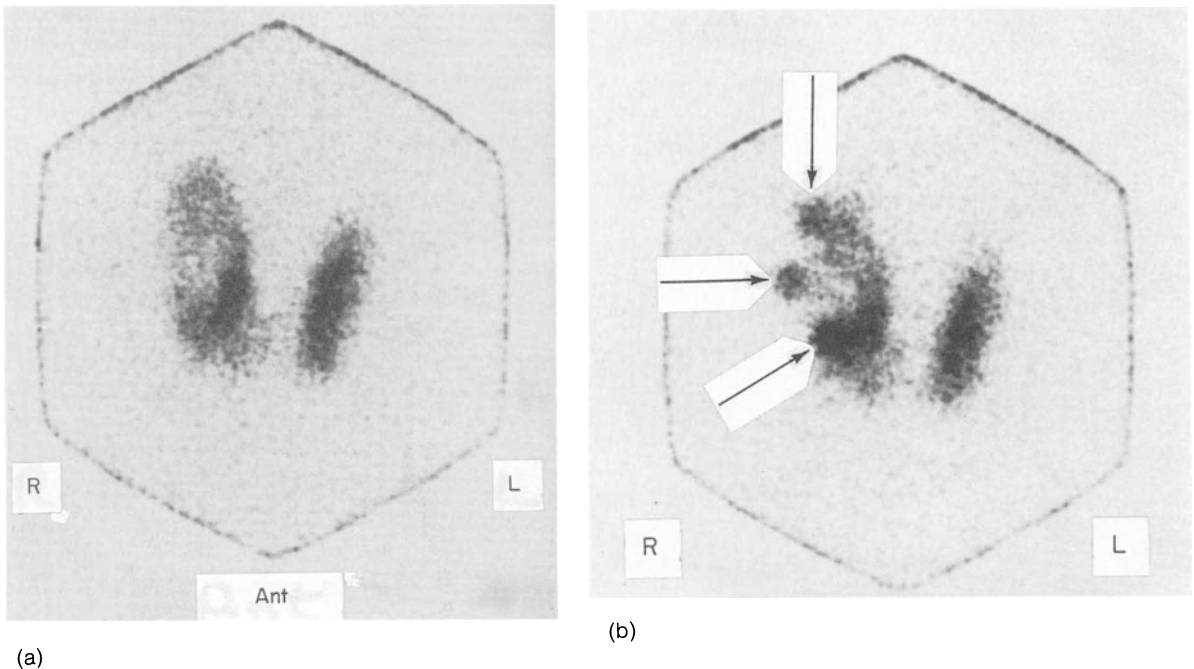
Thyroid scintigram made 3 hours after an oral dose of  $200 \mu\text{Ci}^{123}\text{I}$ . The patient had a mobile right-sided nodule and she was clinically and biochemically euthyroid. The nodule is hyperfunctional since there is more uptake than in the surrounding thyroid. However, there is not total suppression of normal tissue. For complete evaluation it is necessary to use a radioactive marker placed on or around the nodule to demonstrate that what is felt and what is seen are one and the same.
